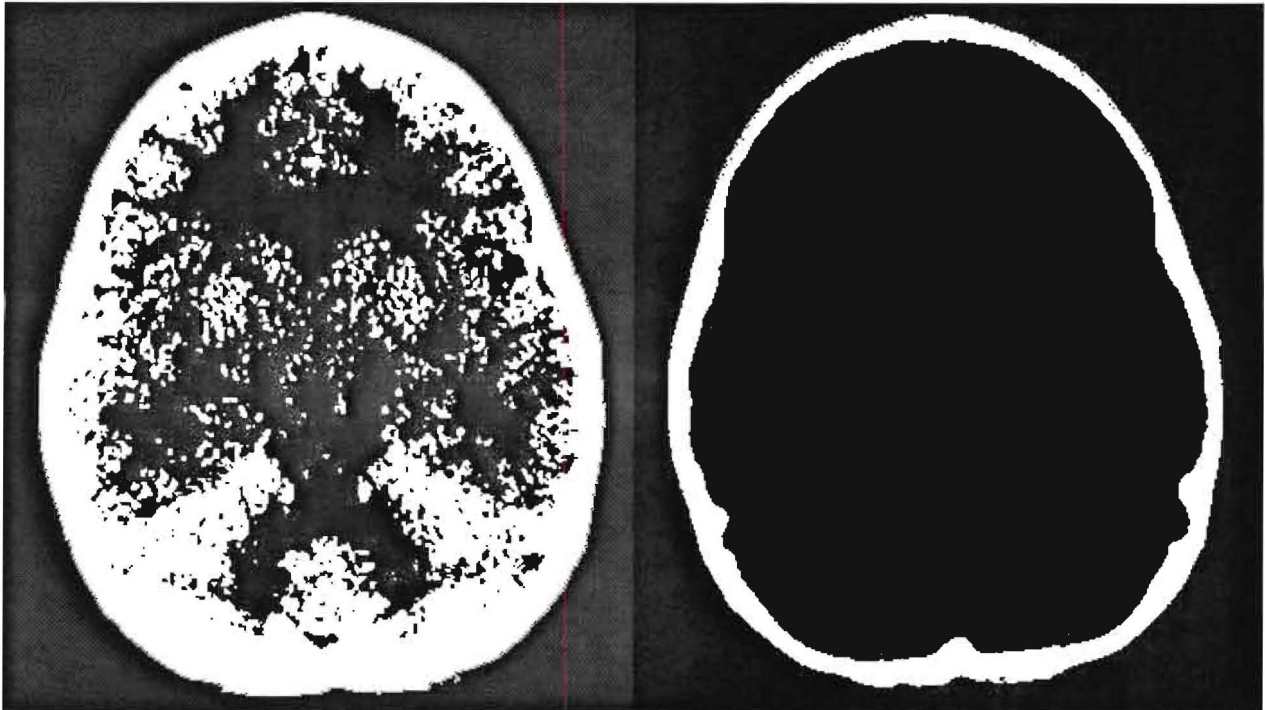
The images show the skull clusters resulting from segmenting a normal brain CT scan. The image on the left has been segmented using FCM and the one on the right with FMLE.
